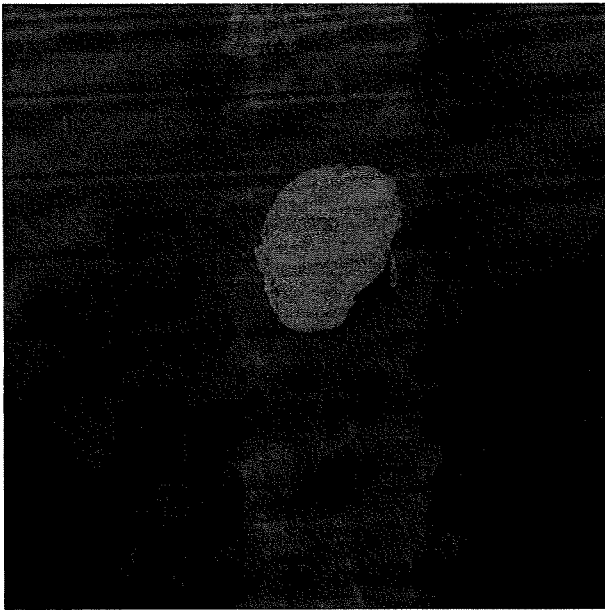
Plain abdominal X-ray, frontal view, obtained three months after embolization. No coil migration or compaction is seen.
